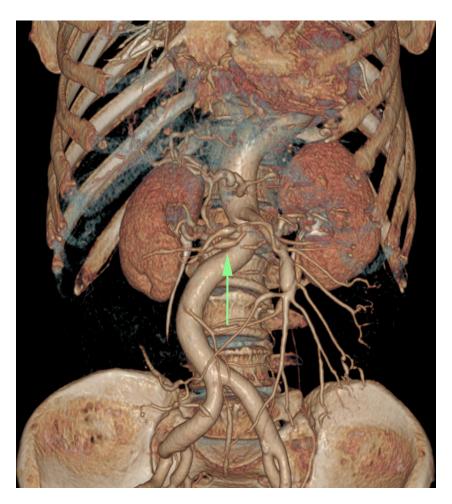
Emergency contrast-enhanced three-dimensional (3D) CT demonstrating superior mesenteric artery (SMA) dissection with distal branch dilation, suggesting an aneurysm formation. The arrow indicates the bleeding vessel.
